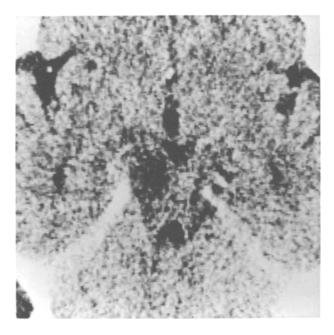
Enlarged CT scan at the level of the tentorial notch showing a hypodense lesion in the left ventral aspect of the brainstem in a patient with left petroclival meningioma (and hemiplegia on the right side) on the fifth postoperative day. The BAEP of this patient are shown in Fig. 7
